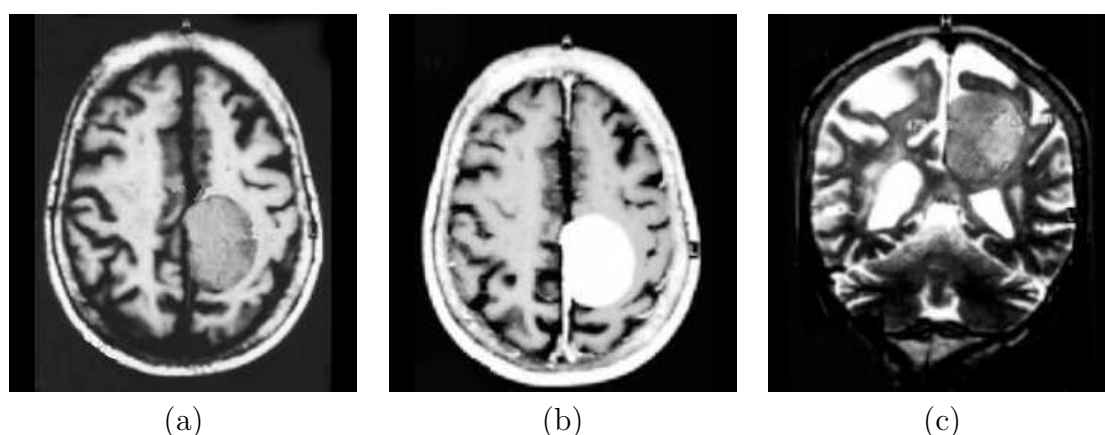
Meningioma tumor. a) Axial slice of T1-weighted image. b) The same tumor on contrast enhanced T1-weighted image. c) Coronal view of T2-weighted image [Emedicine, 2005].
